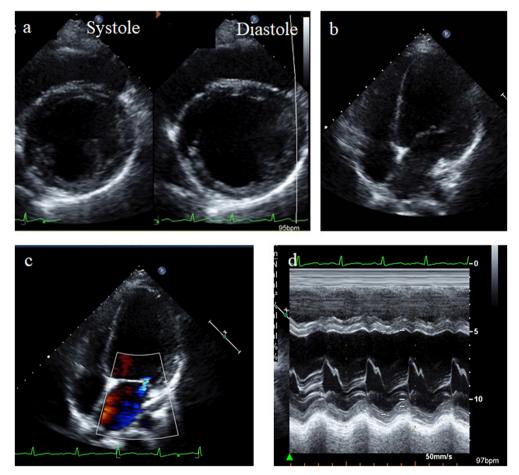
Echocardiography of the present case at initial evaluation. (a) Dilatation of the left ventricle and impaired left ventricular systolic function were demonstrated. (b) The apical four-chamber view showed the enlarged left ventricle. (c) The color doppler image of the apical four-chamber view demonstrated mild mitral regurgitation. (d) The image of M-mode of left ventricle showed impaired left ventricular systolic function
